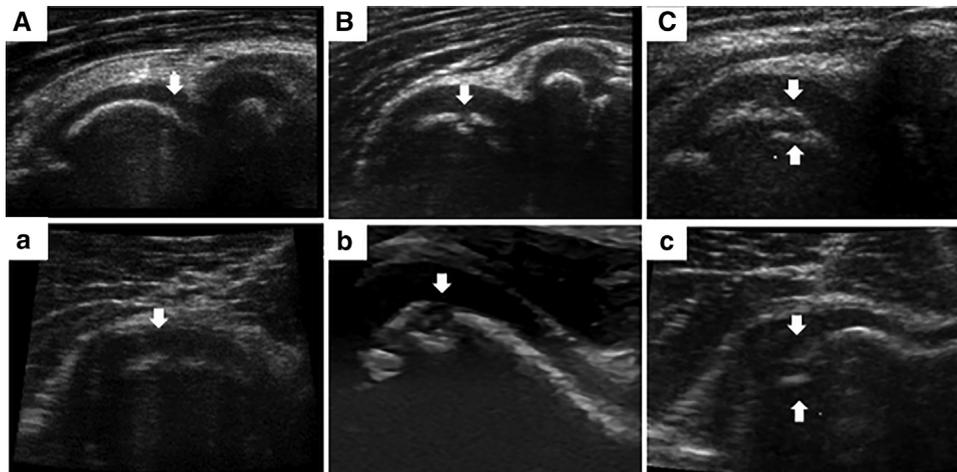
Ultrasonographic images of the humeral capitellum. Irregularity (arrow) is seen on the capitellum (A: anterior long-axis view and a: anterior short-axis view). A break in the continuity (arrow) is seen on the capitellum (B: anterior long-axis view and b: posterior short-axis view). Double floor line (arrows) is observed on the capitellum (C: anterior long-axis view and c: anterior short-axis view).
